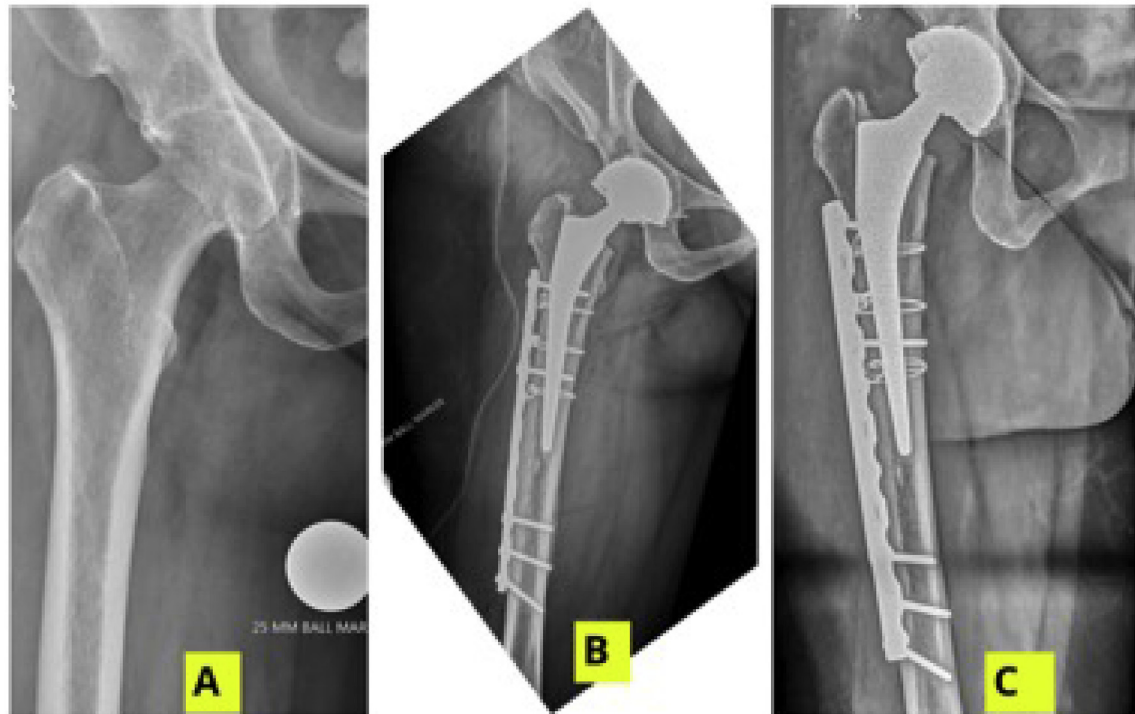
(A) Antero-posterior radiograph of a 56 year old female patient with secondary osteoarthritis of the right hip; (B) Right cemented dual mobility THR with plating for intra-operative periprosthetic femur fracture was done; (C) Follow up radiograph at 15 months.
